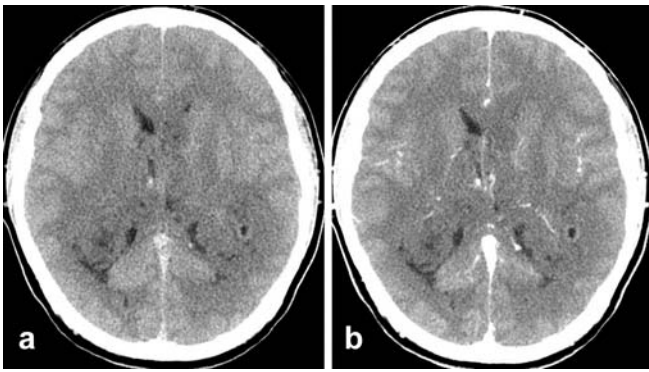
Axial pre- (a) and post- (b) contrast-enhanced computed tomography (CT) of the head shows a large symmetric isodense intraventricular mass without calcifications filling the lateral ventricles and extending into the temporal horns
